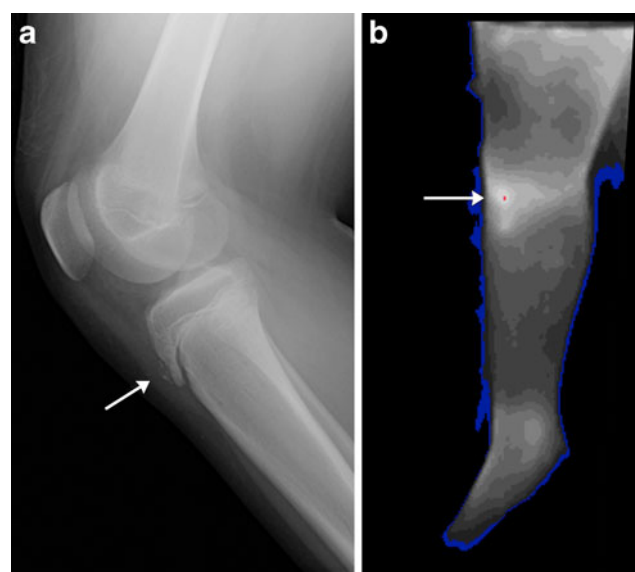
Eight-year-old girl who fell from height. a Lateral view of a knee radiograph reveals fragmentation of the tibial tubercle and soft tissue swelling at the distal insertion of the patellar tendon (*arrow*). b The knee was the warmest segment on DITI (*arrow*), obtained 5 h after the trauma. Clinically the patient had anterior knee point tenderness and was diagnosed as having a fracture
